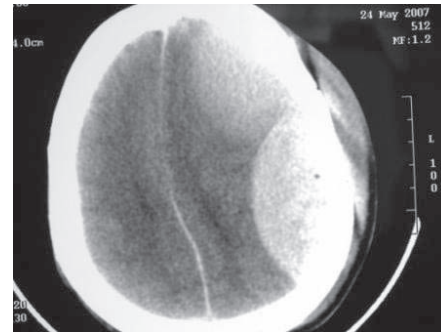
Pre-operative CT scan of head showing two biconvex hyperdense, extra-parenchymal lesions, suggestive of EDH.
